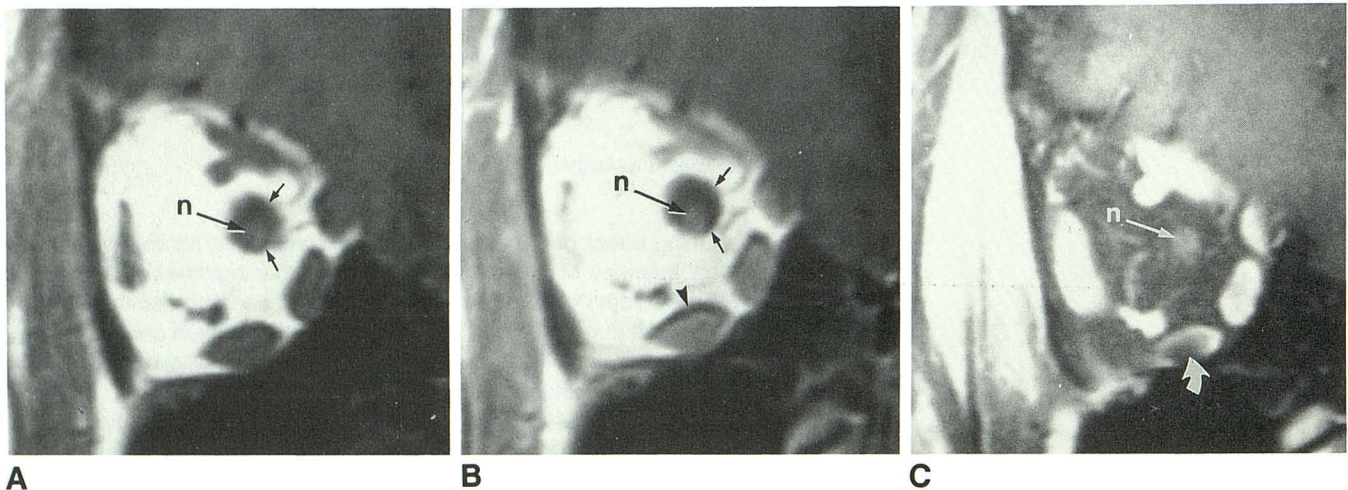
A–C, Coronal T1-weighted spin-echo MR images of a normal orbit before IV injection of gadopentetate dimeglumine (A) after contrast injection (B), and with fat suppression after contrast injection (C). In B, chemical-shift misregistration results in an artifactual black band (arrowhead) at superior margin of medial and inferior rectus muscles and increases prominence of the optic nerve sheath (arrows) superiorly. This effect is not evident with fat suppression (C). With fat suppression, in C, there is an artifactual signal void (curved arrow) within inferior rectus muscle, believed to be related to magnetic susceptibility differences between the muscle and air within the adjacent maxillary sinus. The increased signal intensity of the superior and inferior ophthalmic veins, seen in B and especially in C, is probably caused by T1 shortening of slow-flowing blood by gadopentetate dimeglumine. The enhancement is more obvious with fat suppression (C) owing to increased contrast between the vessels and surrounding fat. (n = optic nerve)
